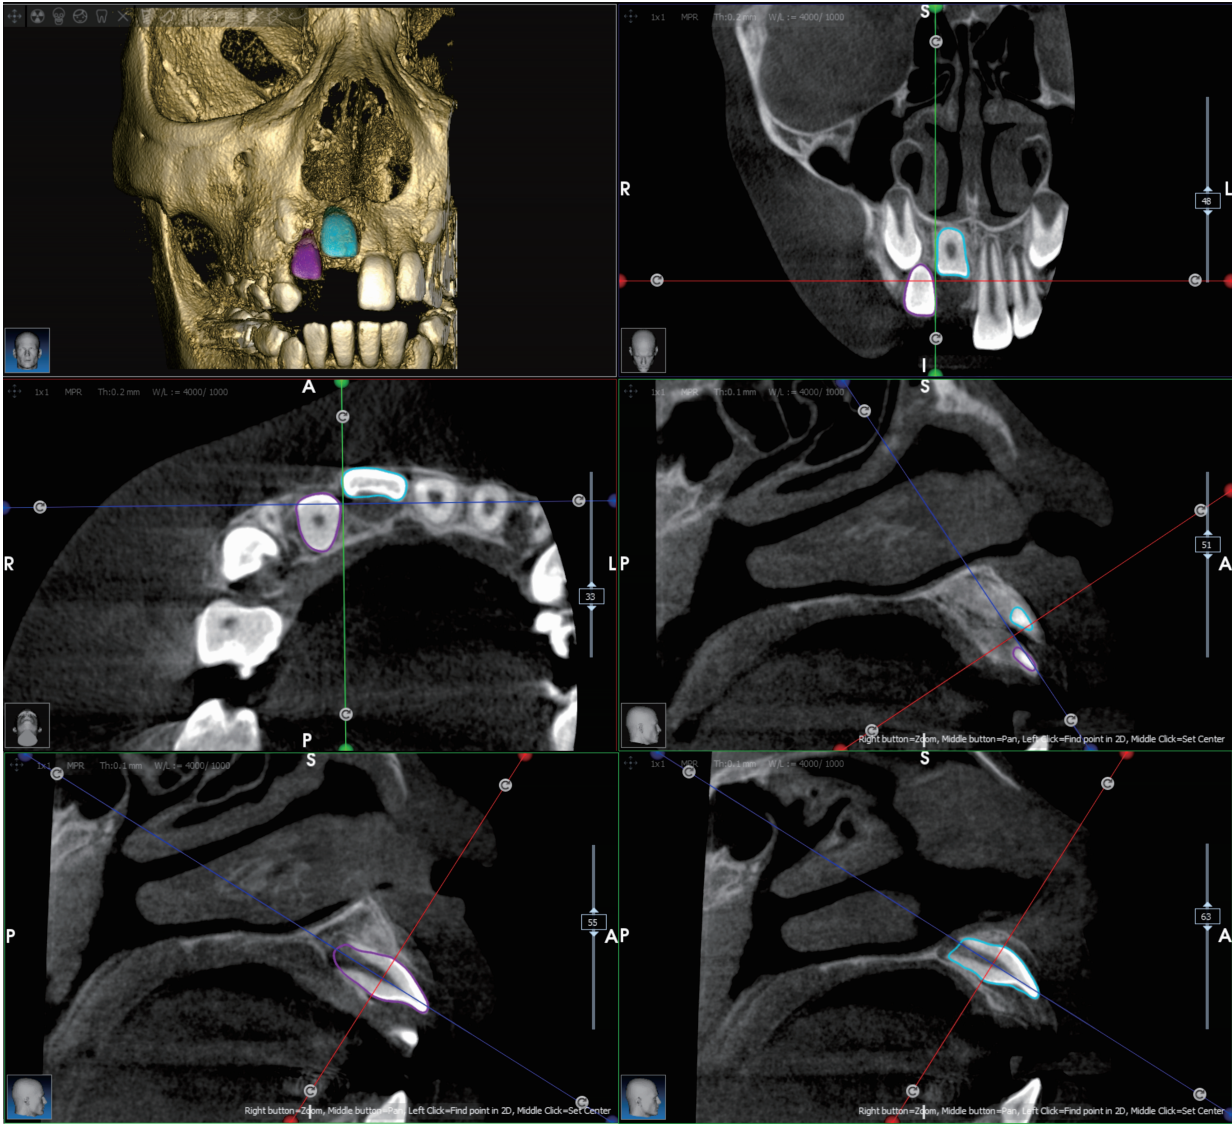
Cone Beam Computed Tomography (CBCT) showed tooth 11 with opened apex, which was adjacent to the inferior of dextral nasal base.
